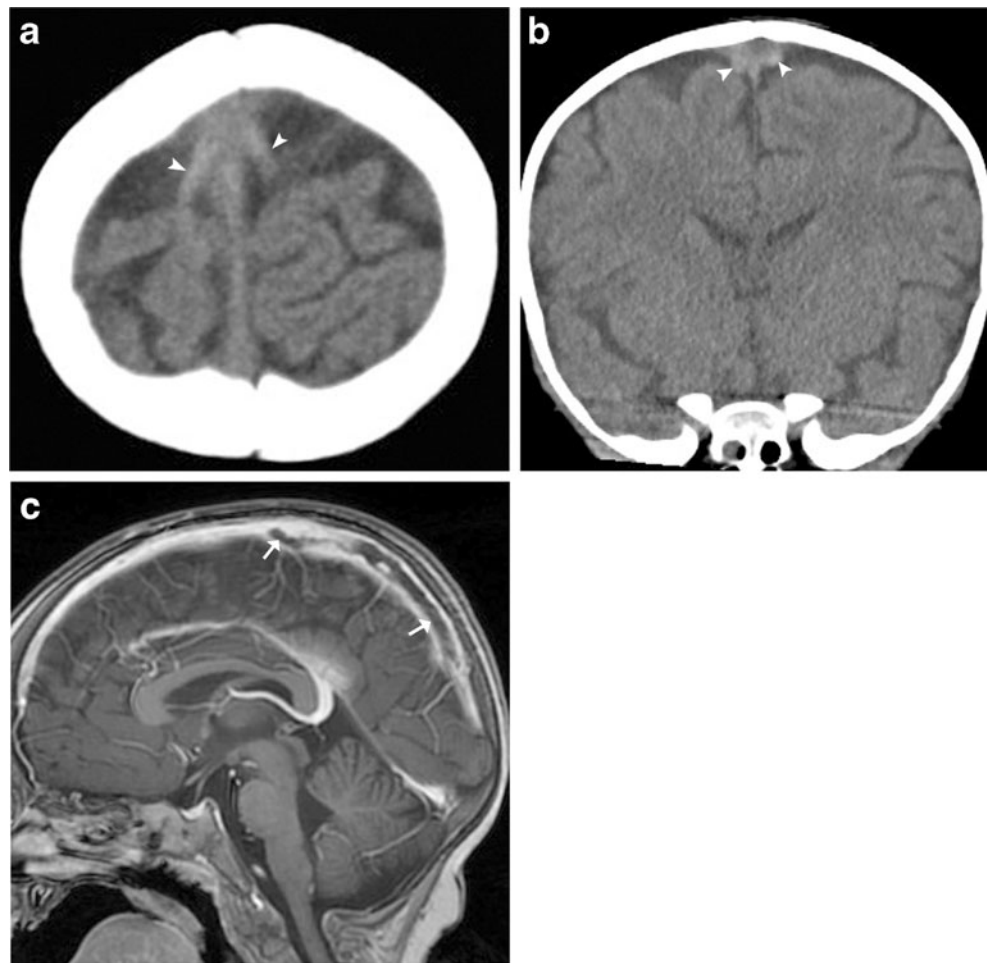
Iron deficiency anemia and sinovenous thrombosis in a 7-month-old girl with seizures and vomiting. Axial unenhanced CT (a) and coronal CT reformation (b) show distention and increased attenuation of cortical veins (*arrowheads*). c Sagittal enhanced 3-D SPGR MRV confirms extensive hypo-intense thrombus within the superior sagittal venous sinus (*arrows*)
